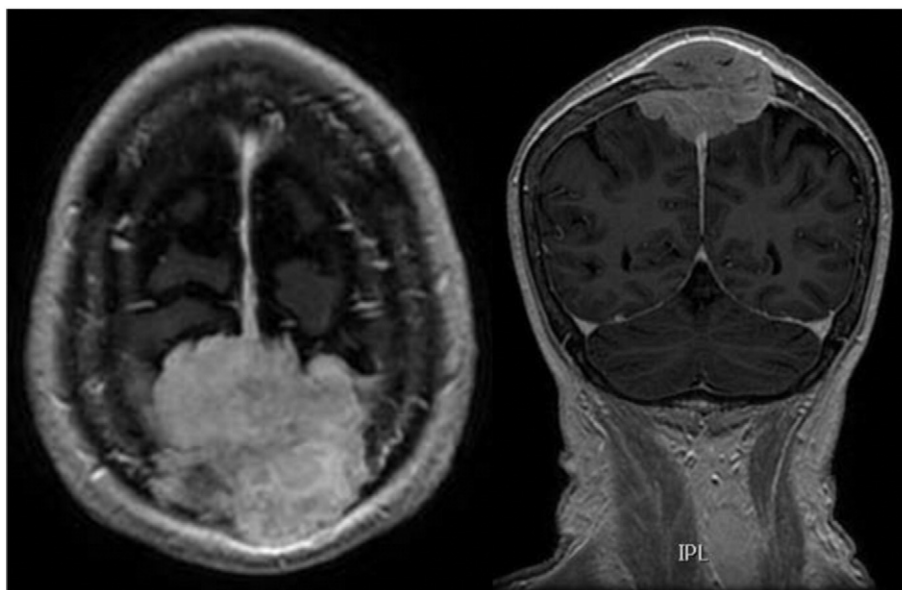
Preoperative brain MRI with gadolinium.
